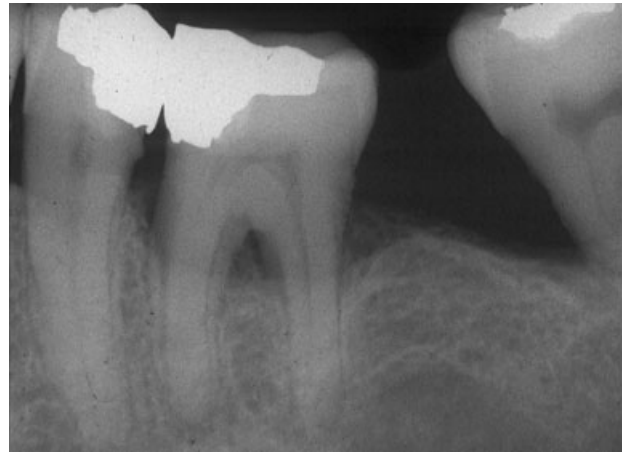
A lower left first molar tooth with concurrent endodontic and periodontal diseases that do not communicate. This tooth has a pulpless, infected root canal system with chronic apical periodontitis as a result of breakdown of the amalgam restoration and the presence of mesial caries. There was no response to pulp sensibility testing and the radiograph shows a small periapical radiolucency associated with the mesial root. The patient has generalized marginal periodontal disease with the typical deep, wide-based periodontal pocket seen with periodontal disease. The radiograph shows more advanced crestal bone loss associated with this tooth than with the adjacent teeth which have clinically normal pulps. (Reproduced with permission and courtesy of the *Journal of the New Zealand Society of Periodontology*.)
